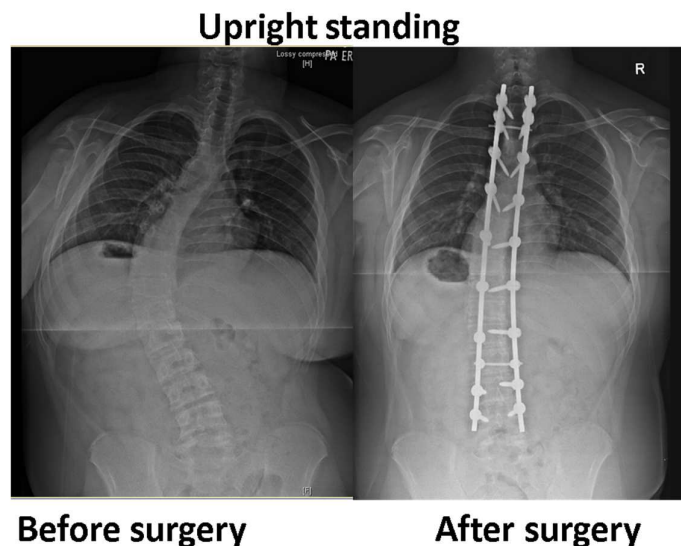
X-ray image of PT2 with scoliosis spine before and after instrumentation surgery. The convexity of the spine was to left side.
